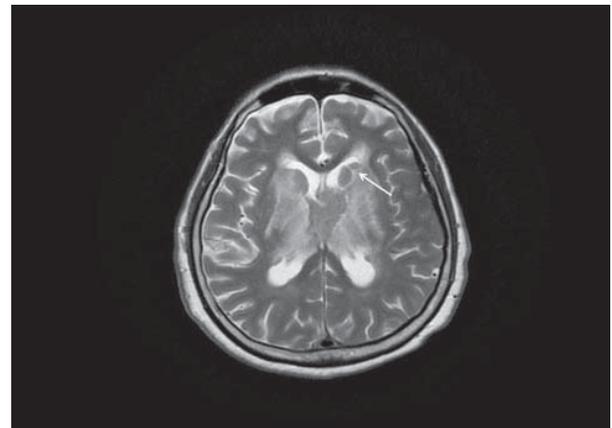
T2W axial MR image showing diffuse iso-intense intraventricular masses with CSF cleft (arrow).
